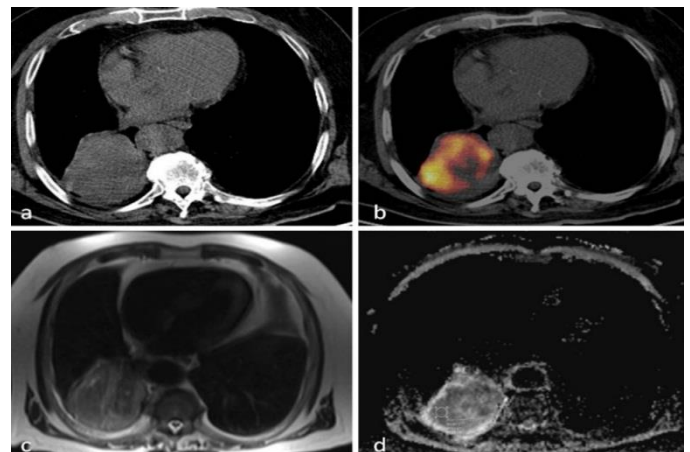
A: Axial CT image reveals right lower lobe mass. B: Corresponding PET/CT image at the same image position revealing a maximum SUV of 10.2. C: T2-weighted HASTE MR image revealing a homogenous tumor signal. D: Corresponding ADC map shows low signal intensity at the periphery of the tumor (ADCmin= 0.75 × 10⁻³mm²/s).
